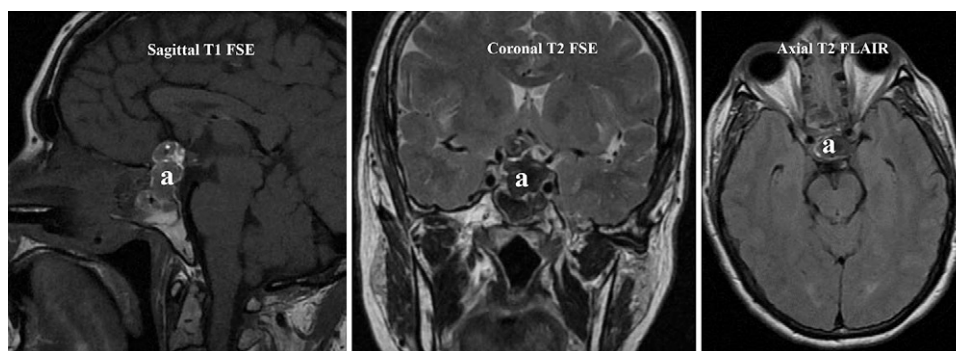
Brain MRI scans showing blood and hemostatic material (a) in the sella turcica with suprasellar extension and superior displacement of the optic chiasm.
